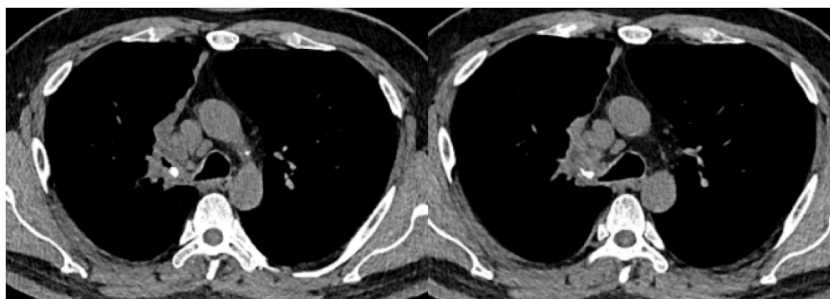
Chest CT scan shows a calcified lesion at the opening of the right upper lobe bronchus.
